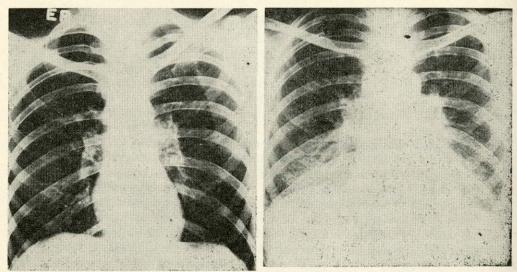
Pulmonary infiltrations associated with eosinophilia in a girl of 21 with neurodermatitis and seborrheic dermatitis. A. Chest x-ray shows no abnormalities. B. Seven months later, lower lobes show diffuse reticular infiltrations; accentuated hilar markings.
